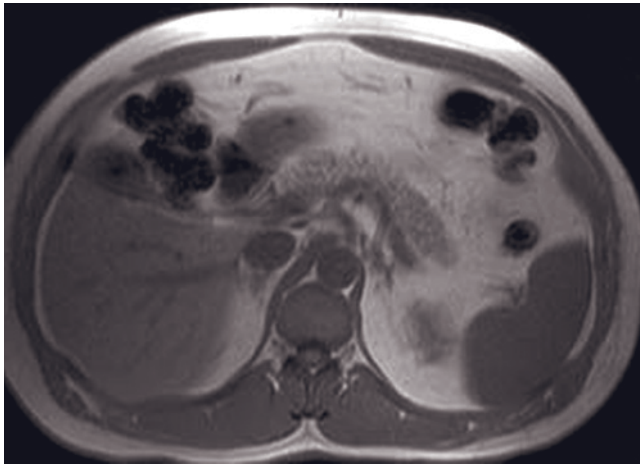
Aldosteronoma. Coronal T2-weighted HASTE (a), T1-weighted GE (b), T1-weighted out-of-phase GE (c), and 90-s postgadolinium fat-suppressed GE (d) images. A 3.5-cm left adrenal aldosteronoma is present (arrows, a, b). The mass is moderately low in signal intensity on the T2-weighted image (a). The mass drops in signal from in-phase (b) to out-of-phase (c) images, reflecting the presence of intracytoplasmic lipid. On the postgadolinium image (d) the mass enhances in a relatively homogeneous fashion. T1-weighted GE (e), T1-weighted out-of-phase GE (f), immediate postgadolinium T1-weighted GE (g), and 90-s postgadolinium fat-suppressed GE (h) images in a second patient with a small left adrenal aldosteronoma showing the same characteristics as described above.
